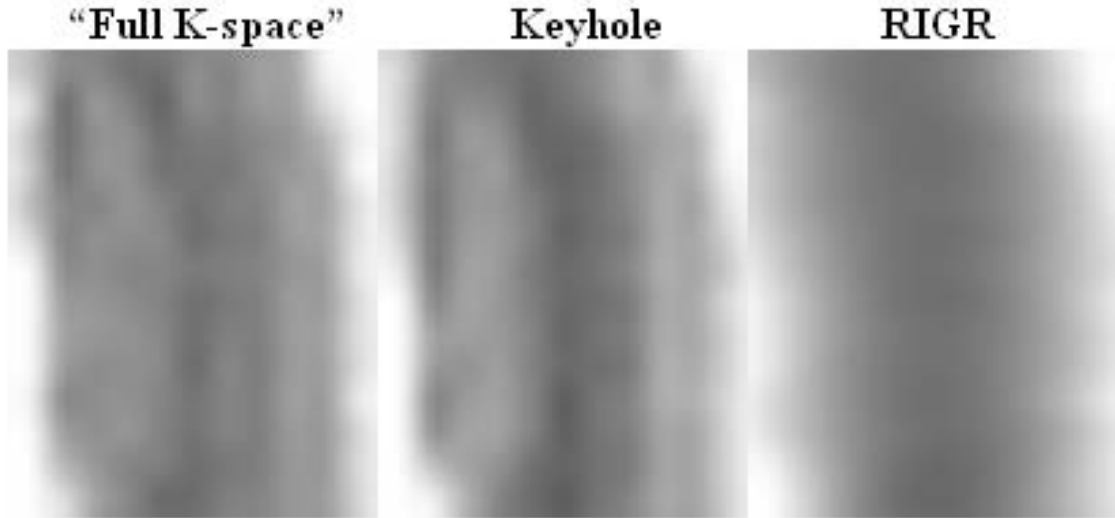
T2 maps of “full k-space” and “shared k-space” reconstructed MRI. The upper, middle and lower rows show the “full k-space”, keyhole and RIGR reconstructed MRI data and its corresponding T2 map, respectively. It is apparent that T2 map from keyhole reconstructed MR images approximates the “full k-space” T2 map much better than that from RIGR data. Note: the three proton density weighted images shown here are identical.
